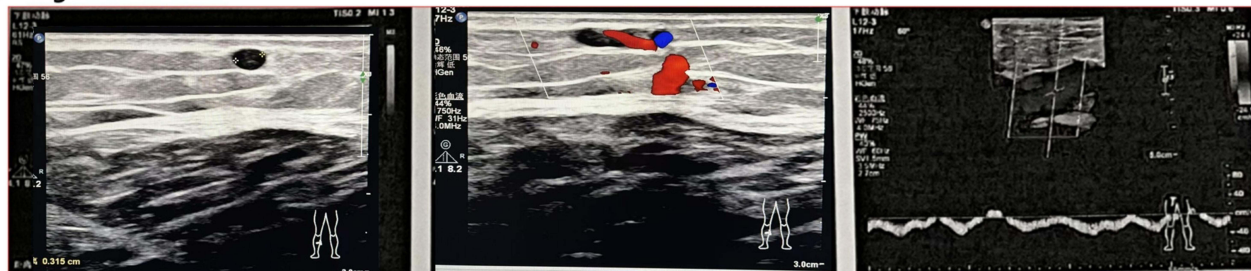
Venous ultrasound images showed a thrombus in the intermuscular veins in the left calf (A) and slightly varicose right great saphenous vein (B) in the calf of another representative patient in the Non-device group 7 days after surgery. (A) The main vein of the left lower limb was displayed, and there was no obvious abnormality in its course. A slightly dilated vein can be seen between the left calf muscles, with a low echo pattern inside with a width of approximately 3.0 mm. The lumen deformation of the probe compression was not obvious, and no obvious blood flow signal was seen inside. (B) The main vein of the right lower limb was displayed. The right great saphenous vein in the lower leg is slightly tortuous, with low echo filling inside, which is 3.2 mm wider. The lumen is slightly deformed when the probe is compressed. CDFI: small blood flow signals are seen around the low echo in the lumen. (A and B) no obvious solid echo was observed in the lumen of the remaining right lower limb, and the lumen can be closed when the probe is compressed. CDFI+ PWV: The blood flow signal was well-filled; there was no obvious abnormality in the direction and speed of blood flow in a calm state. Abbreviations: PWV, Pulsed-wave Doppler ultrasound; CDFI, Color Doppler flow imaging.
